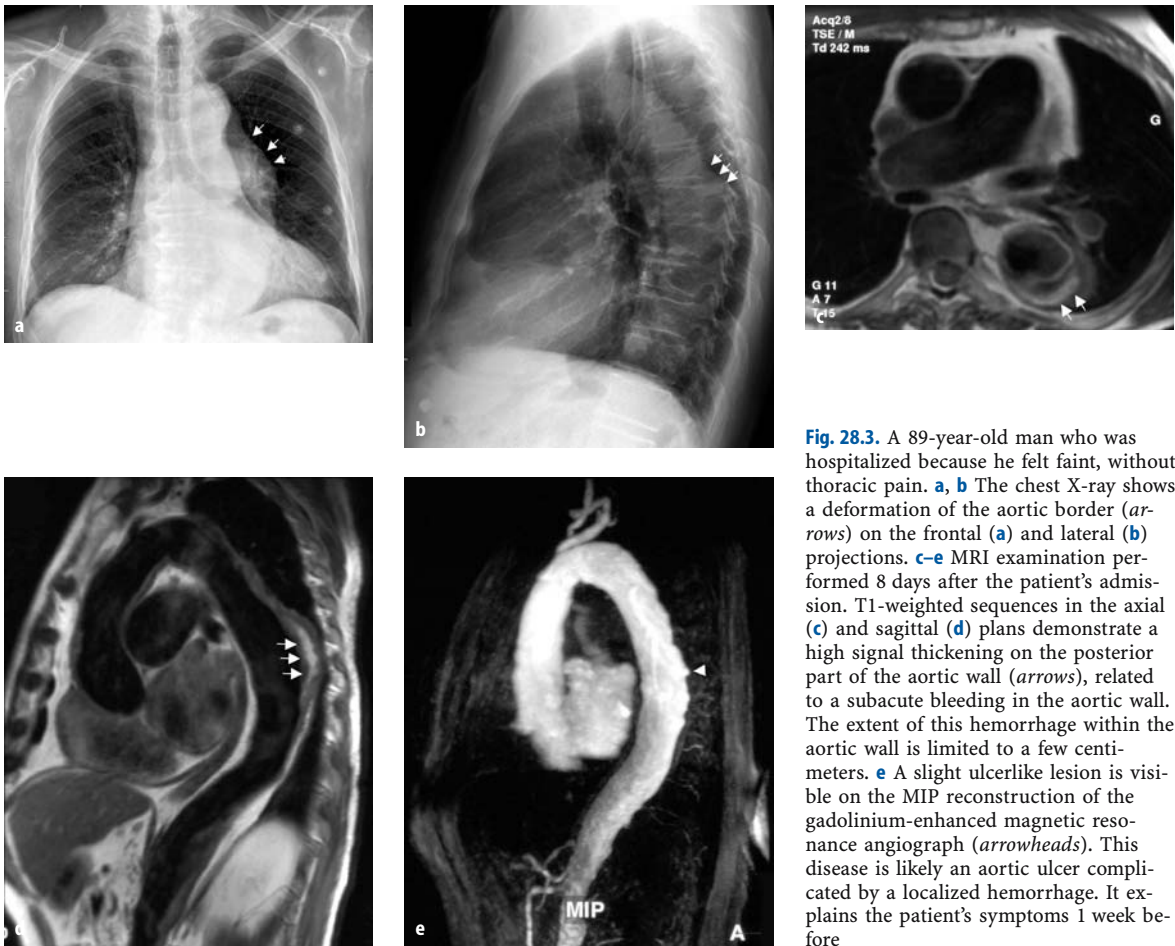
A 89-year-old man who was hospitalized because he felt faint, without thoracic pain. a, b The chest X-ray shows a deformation of the aortic border (*arrows*) on the frontal (a) and lateral (b) projections. c–e MRI examination performed 8 days after the patient's admission. T1-weighted sequences in the axial (c) and sagittal (d) plans demonstrate a high signal thickening on the posterior part of the aortic wall (*arrows*), related to a subacute bleeding in the aortic wall. The extent of this hemorrhage within the aortic wall is limited to a few centimeters. e A slight ulcerlike lesion is visible on the MIP reconstruction of the gadolinium-enhanced magnetic resonance angiograph (*arrowheads*). This disease is likely an aortic ulcer complicated by a localized hemorrhage. It explains the patient's symptoms 1 week before
